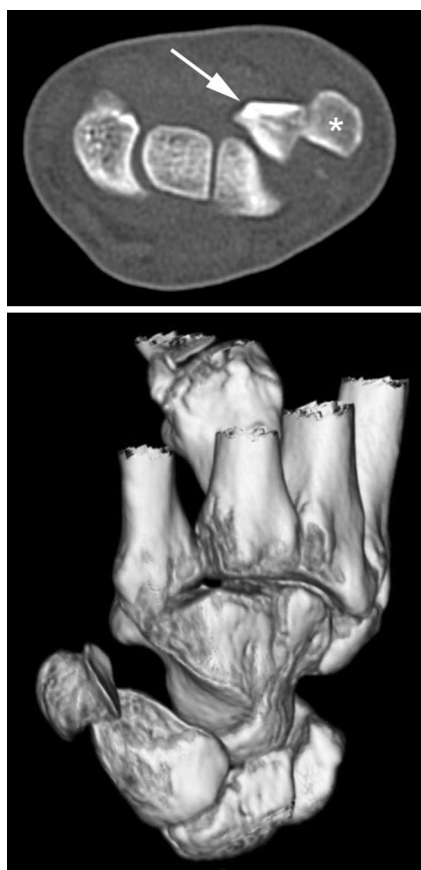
CT scan taken at day of injury. The axial plane shows volar dislocation of the triquetrum (*white arrow*) with entrapment of the pisiform bone (*asterisk*) behind its dorsoulnar margin. The saddle shaped geometry of the triquetro-hamate joint, which provides the mechanism of this injury, can be observed in the 3D reconstruction of the CT scan
